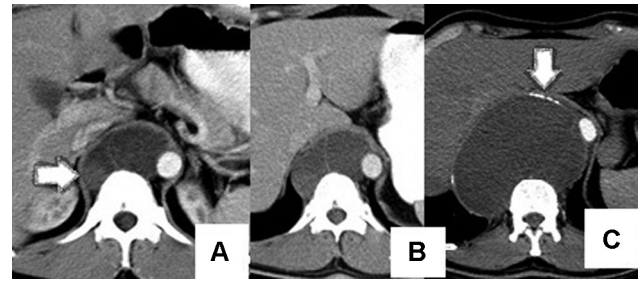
Contrast-enhanced computed tomography (CECT) at presentation (A) showing a predominantly cystic retrocrural mass with a small eccentric solid component on the right side (arrow); CECT done a year later (B), showing a mild increase in the retrocrural mass and CECT done 24 years postorchidectomy (C), showing significant increase in size of the retrocrural lesion with only cystic component, thin internal septations, and calcification (arrow).
